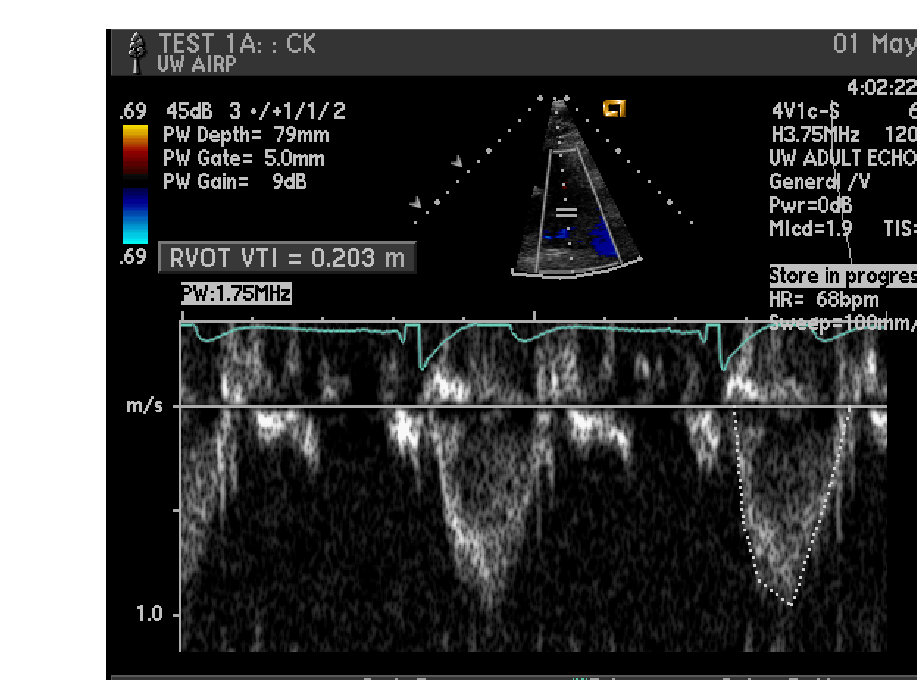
Pre exercise image of pulmonary artery generated by ultrasound. Heart rate = 68 bpm and the measured VTI = 0.203 m
